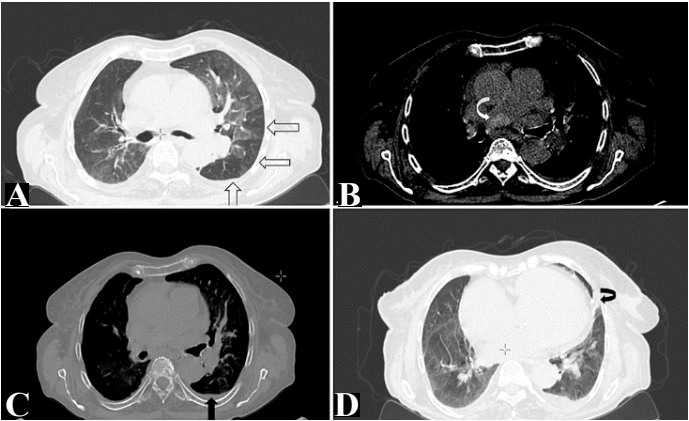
Mixed lung and mediastinal window images of non-contrast CT: a. multiple areas (white arrows) of mosaic perfusion, b. enlarged main and right pulmonary arteries (36 mm and 28 mm, respectively), embolus in the right pulmonary artery (white curved arrow), c. minimal pleural effusion in the left hemithorax (black arrow), d. atelectasis area (black curve arrow), and enlarged right heart was seen respectively.
